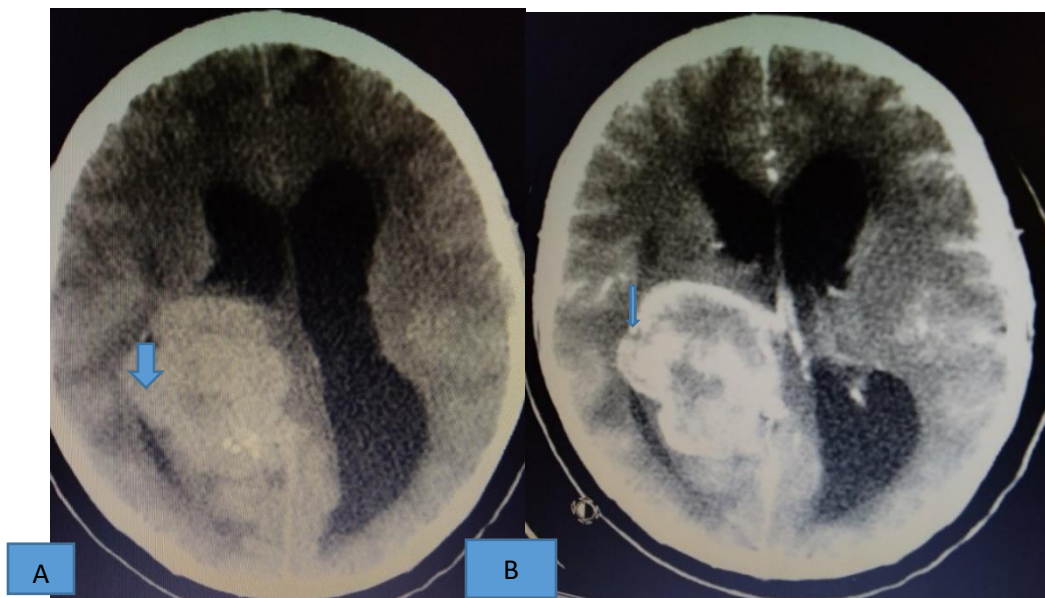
Pre (A) and post IV contrast (B) CT scan of the brain showing a heterogeneous mass (arrow) with solid, cystic and calcific foci due to craniopharyngioma.
